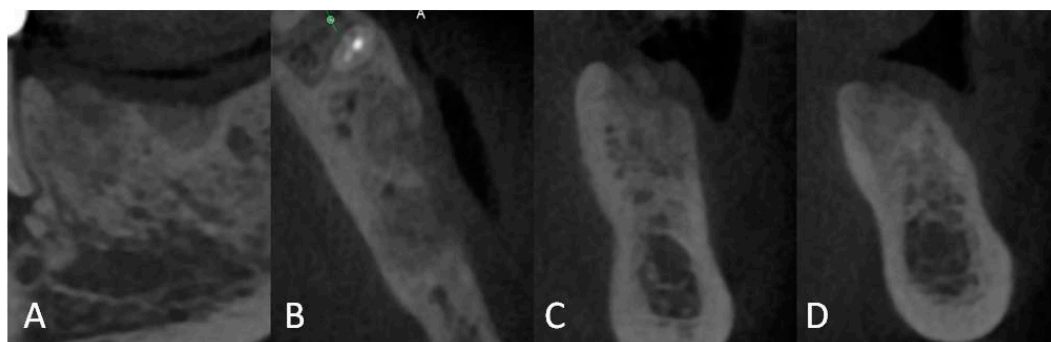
Three-dimensional radiographic analysis (Acteon X-Mind Trium) done four months later, in (A) sagittal and (B) axial projection, and cross-sections of Regions (C) 35 and (D) 36.
